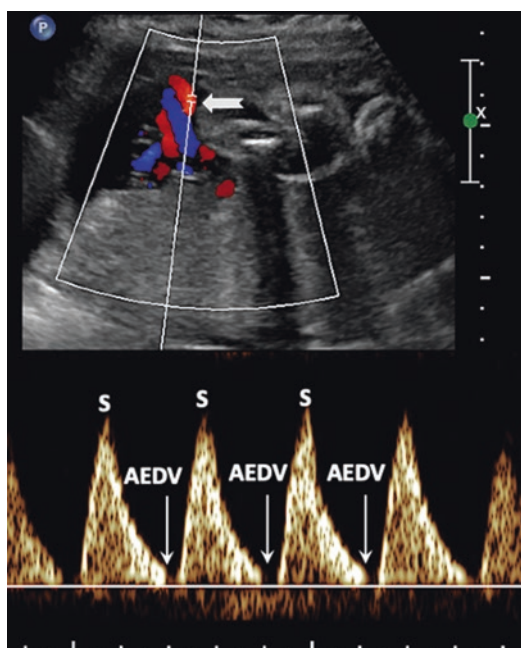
An example of absent end-diastolic velocity in the umbilical artery. Top: Color Doppler-directed pulsed Doppler interrogation of the umbilical vessels. The white arrow points at the Doppler sampling location. Bottom: umbilical arterial Doppler waveforms. *S* peak systolic velocity, *AEDV* absent end-diastolic velocity
